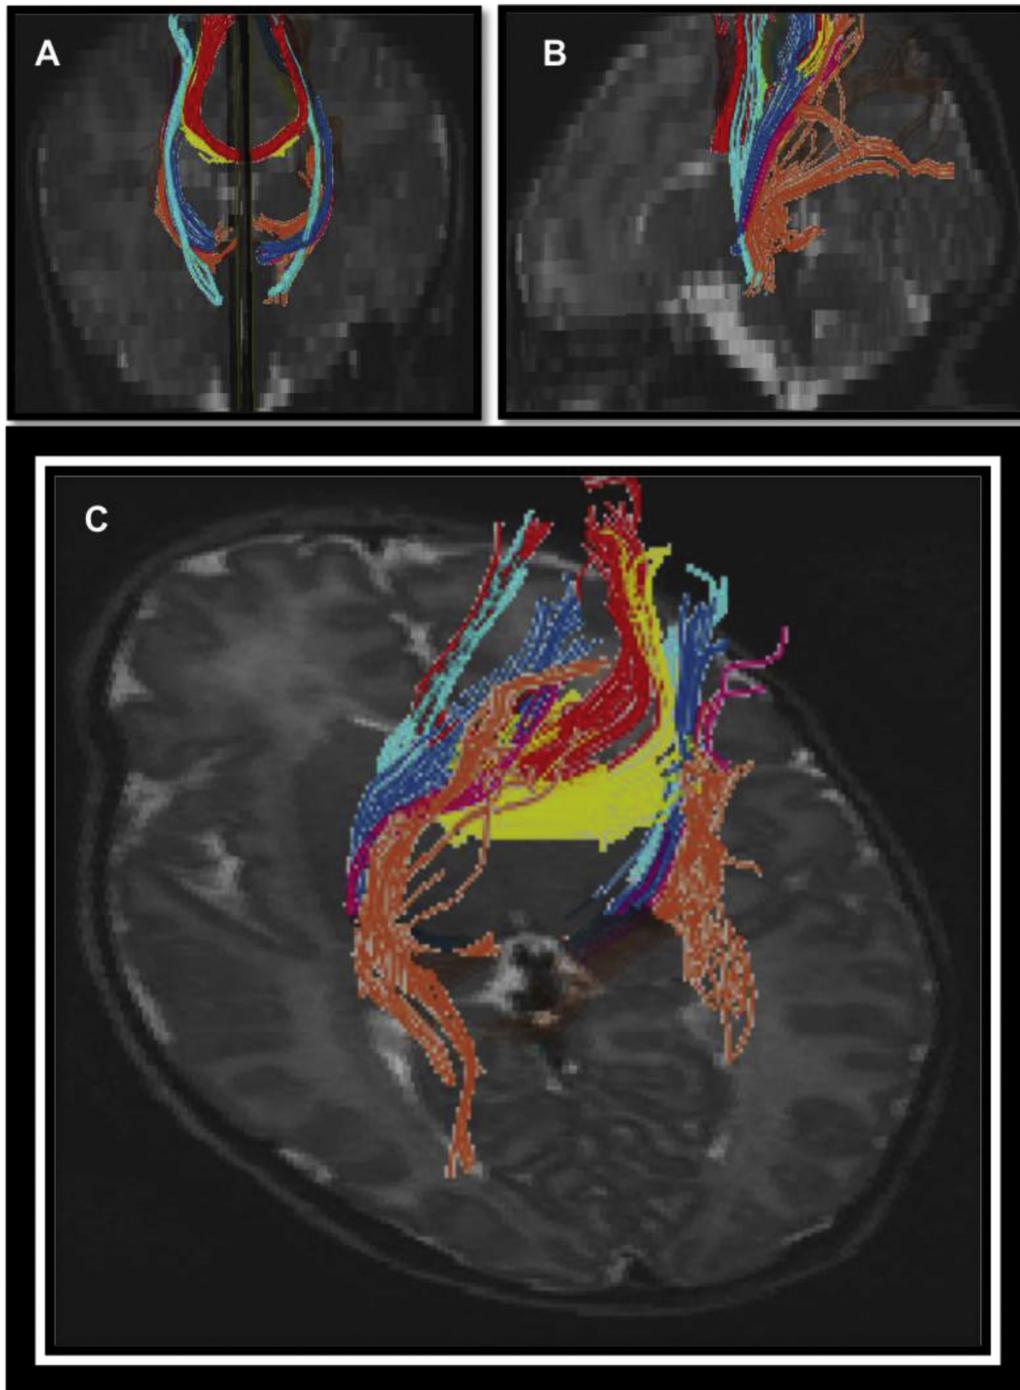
Sensorimotor network tractography superimposed on T2-weighted images in a very preterm infant. Coronal (A), sagittal (B), and axial (C) views of the corticospinal tract (light blue), posterior thalamic radiations (orange), superior thalamic radiations—motor segment (dark blue), superior thalamic radiations—sensory segment (pink), posterior midbody of the corpus callosum (CC; red), and isthmus of the CC (yellow).
